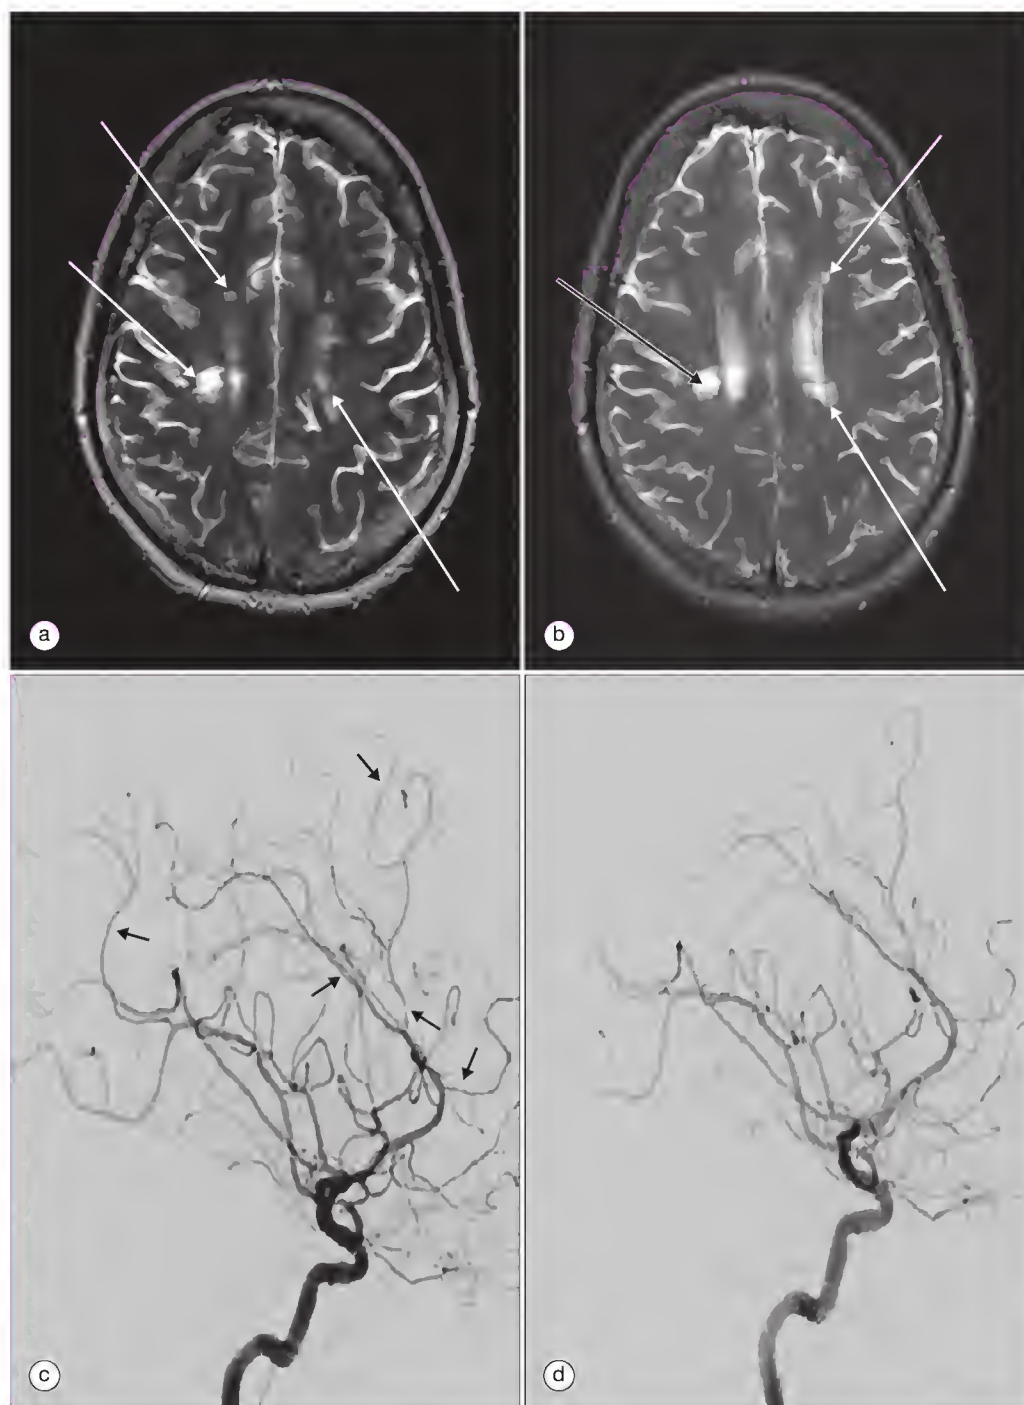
Brain magnetic resonance images (a and b) and cerebral angiograms (c and d) of cerebral vasculitis before (a and c) and after (b and d) immunosuppressive treatment. (a) Brain magnetic resonance imaging with stable multiple remote prior lacunar infarcts (arrows) with no new diffusion weighted or enhancing lesion. (c) Cerebral angiography shows mild improvement (arrows) in the areas of vascular abnormality involving cortical vessels from all intracranial circulatory territories. A 2-mm sidewall left cavernous internal carotid artery aneurysm and a 2-mm right posterior communicating artery aneurysm were unchanged.
